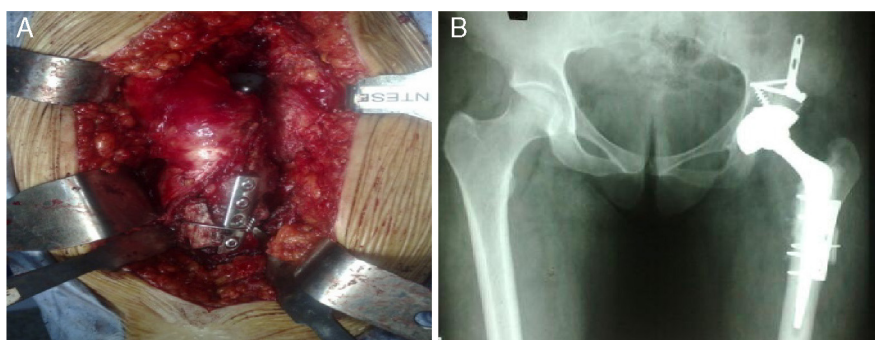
Intraoperative image in which femoral osteotomy in inverted-V and rigid fixation with DCP plate (A) were performed and pelvic X-ray in anteroposterior view showing the attachment after shortening and application of graft cerclage into the osteotomy (B).
